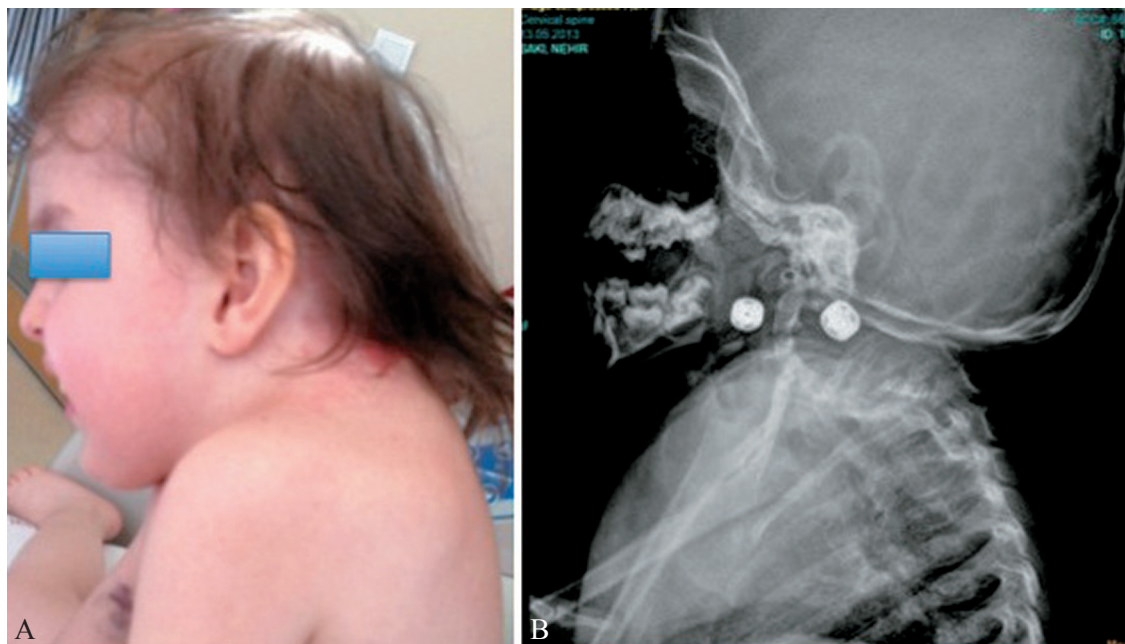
A) Three-year old girl with Klippel-Feil Syndrome; B) cervical radiograph.
